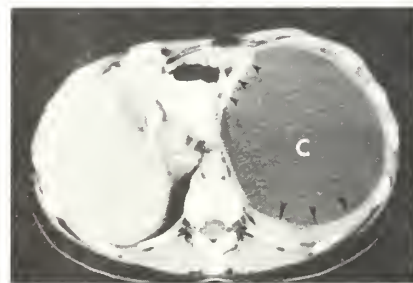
Computed tomography scan of the abdomen shows a large cyst (C) of the spleen with a rim of splenic parenchyma (large arrowheads) and a focal area of calcification (small arrowheads) anteromedially.
